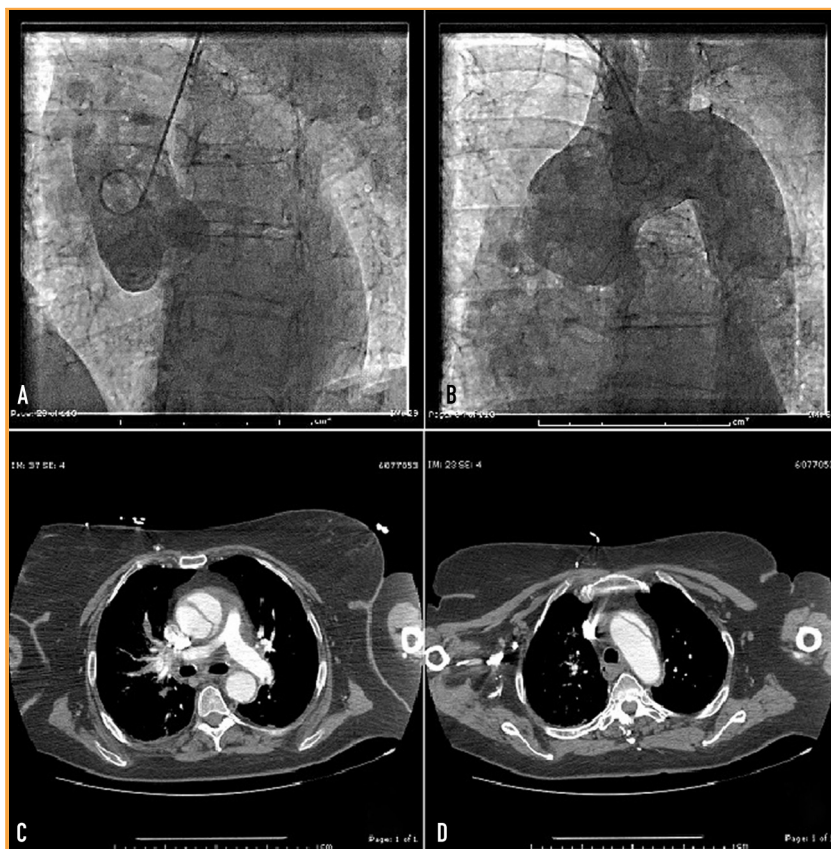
Diagnostic studies in a 70-year-old woman with severe, nonexertional substernal chest pain radiating to the right shoulder. Urgent cardiac catheterization and aortography revealed aortic root dilatation without aortic insufficiency (A, B) and a possible large ascending aortic aneurysm. Computed tomographic angiography of the thorax revealed type A aortic dissection (C, D).
